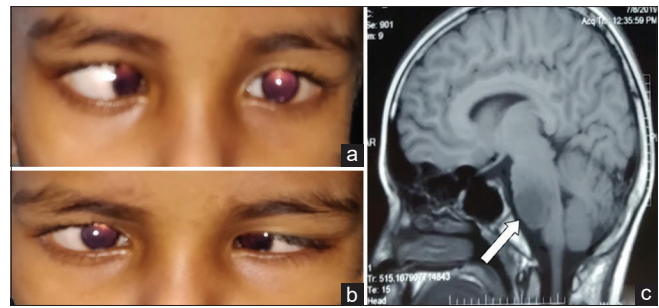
(a and b) Clinical image of patient no. 1 showing the right eye LR palsy with gross abduction deficit and (c) T1W Coronal MRI imaging showing diffuse pontine glioma (white arrow)
